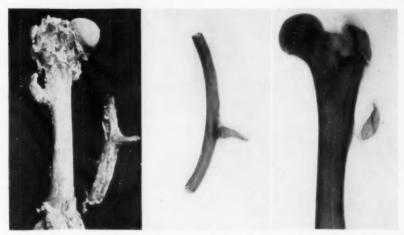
A pedunculated flap of periosteum with a thin film of bone was raised from the femur and also from a rib. The soft parts were sutured beneath them. Photographs and X-ray taken 50 days later. The bone was accidentally broken away from the femur before X-ray was taken.
